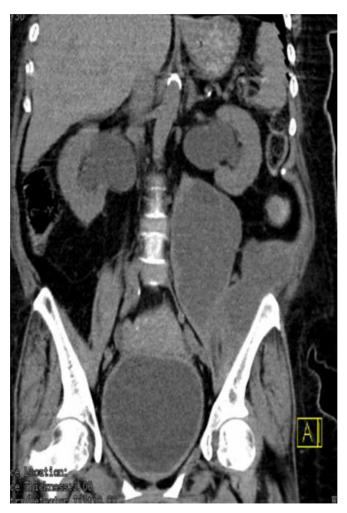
CT-scan of left psoas collection.
